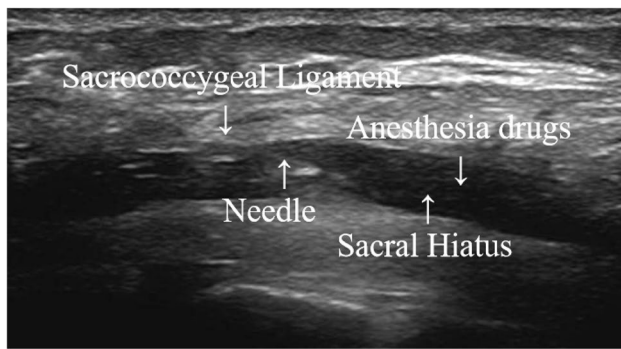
Ultrasound view of the local anesthetic filled the sacral lumen
